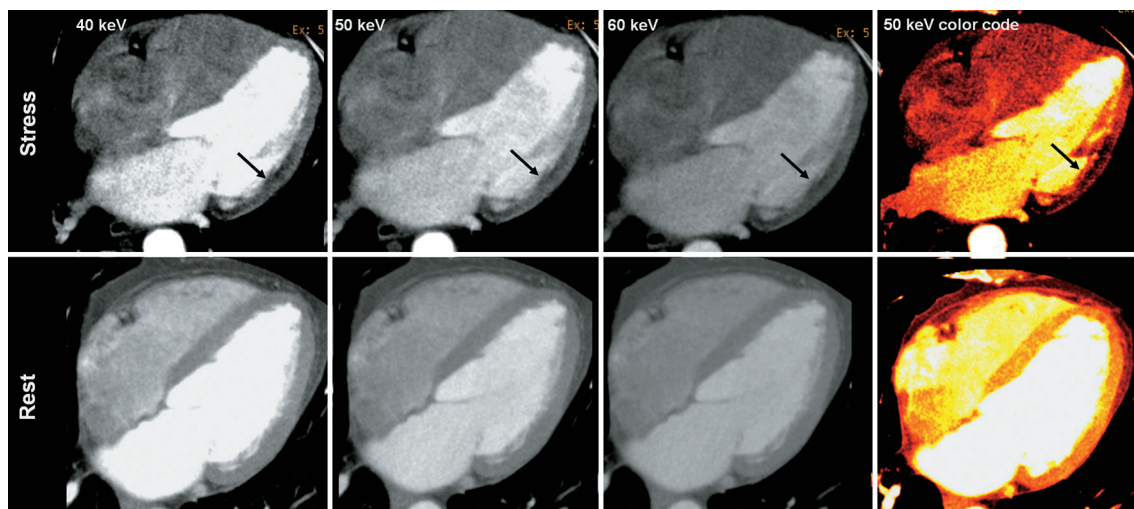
Stress-rest myocardial perfusion using dual energy CT. A fully reversible perfusion defect (arrows) is observed at the left circumflex territory, more clearly depicted at low energy levels.
